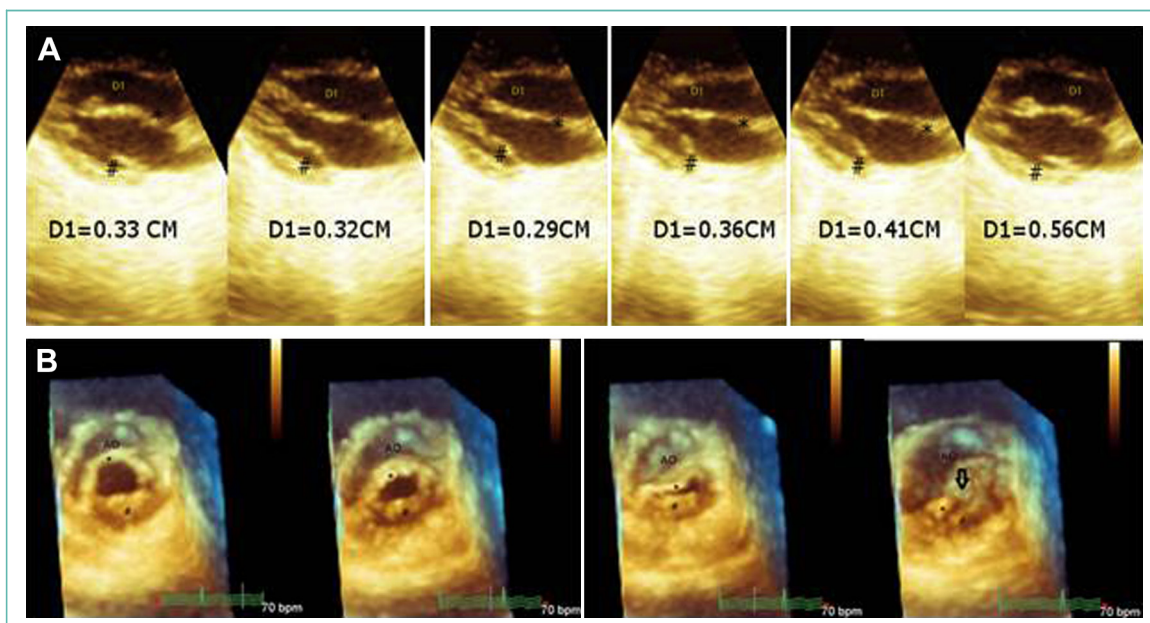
(A) Six parallel thin slices mimicking parasternal long-axis view by 2-dimensional transthoracic echocardiography showing variation in the maximum thickness of the anterior mitral leaflet measured by the multiplanar resetting mode of live/real-time 3-dimensional transthoracic echocardiography. *The anterior mitral leaflet; #the posterior mitral leaflet. (B) The en-face view of the mitral valve from the left ventricular side by live/real-time transthoracic echocardiography seen in various stages of cardiac cycle. The arrow depicts the “reverse doming”/prolapse of the middle (A2) and lateral (A1) scallops of the anterior mitral leaflet as seen from the ventricular side (Video 1) and left atrial side (Video 2). *The anterior mitral leaflet; #the posterior mitral leaflet.
